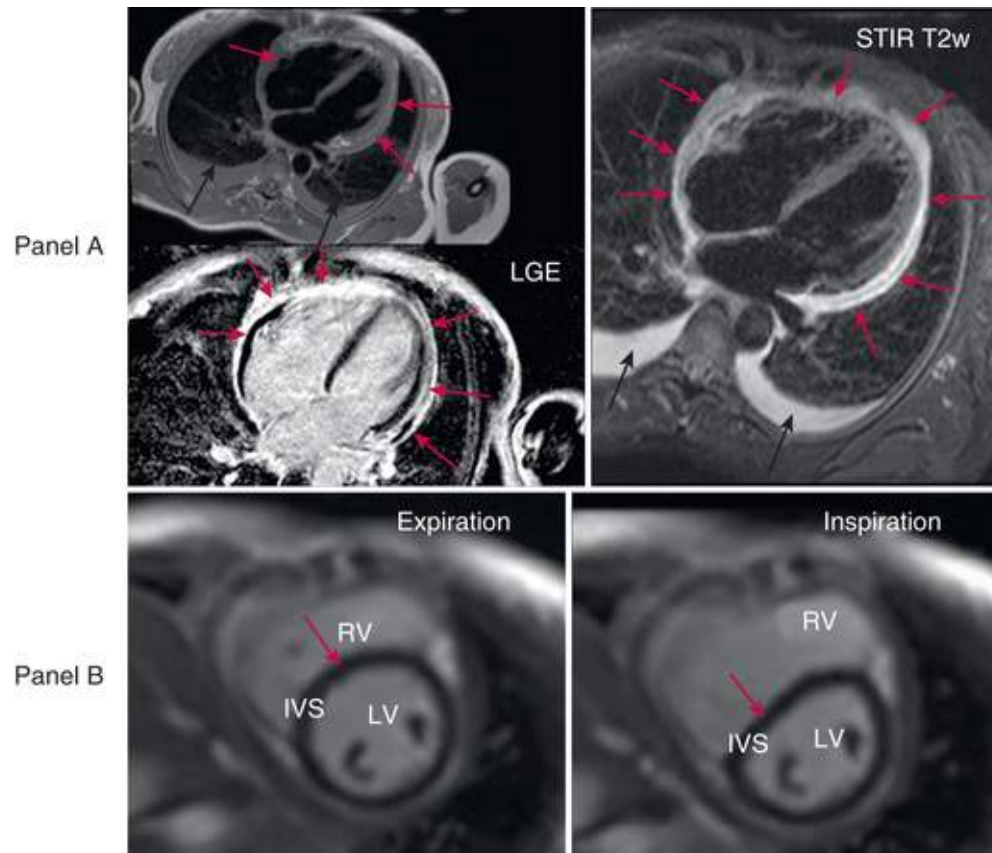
MRI of a patient with active pericarditis and constrictive physiology at presentation. In panel A, pericardial thickening and inflammation are present (*red arrows* indicate late gadolinium enhancement on the left and edema on STIR T2w image on the right). In panel B, real-time MRI reveals septal flattening or a “bounce” (*red arrows*) on inspiration owing to exaggerated ventricular interdependence. *IVS*, interventricular septum; *LGE*, late gadolinium enhancement; *LV*, left ventricle; *RV*, right ventricle. (Modified from Imazio M, Gaita F, LeWinter M: Evaluation and treatment of pericarditis: a systematic review. *JAMA*2016;314:1498.)
